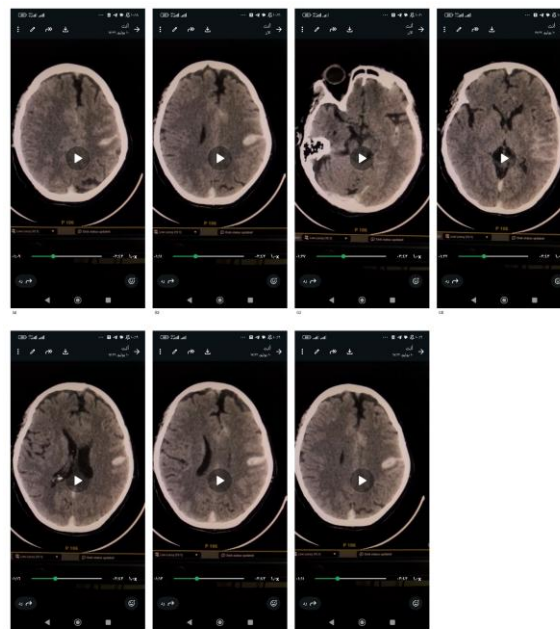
Non- contrast CT brain
